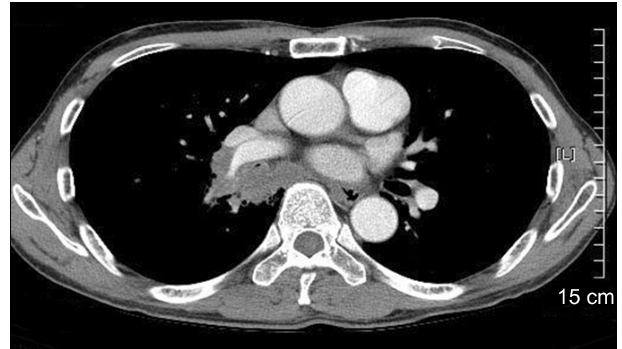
Chest CT showing a pulmonary embolism of the right pulmonary artery and multiple enlarged lymph nodes.
